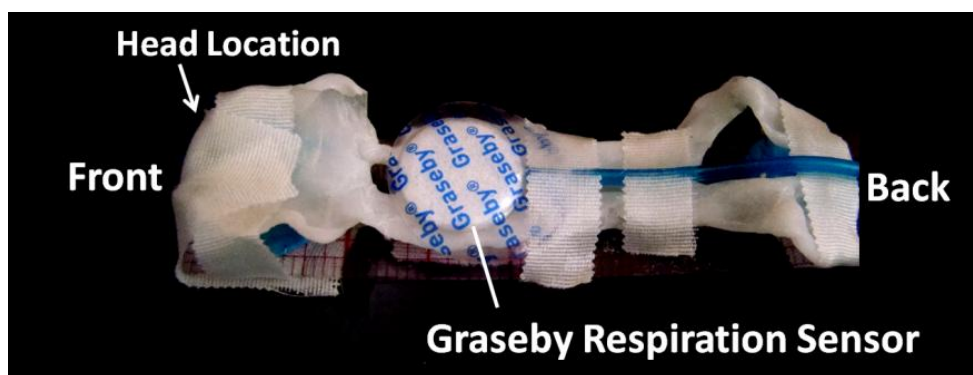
Positioning device for MRI and PET imaging.
